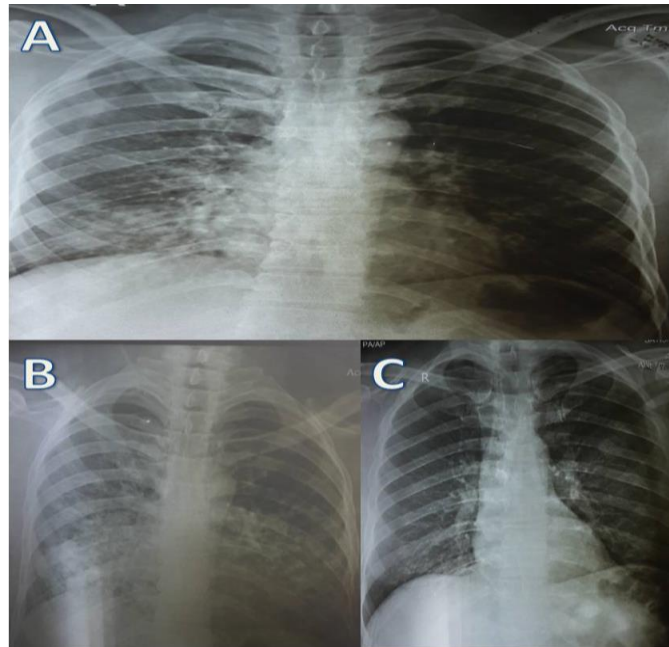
Chest X-ray PA view of patient A) taken on admission day showing lower zone opacities B) Day 7 post aspiration showing further increase in the alveolar opacities C) At discharge showing clearance
